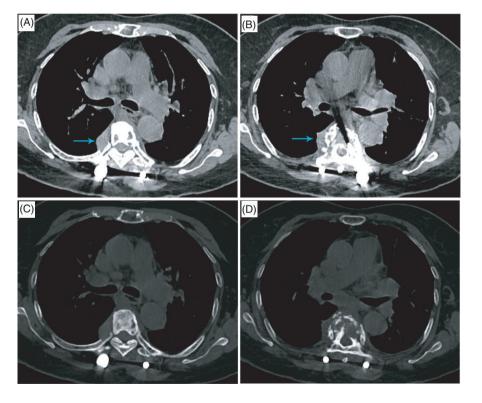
Preoperative and postoperative X-ray examinations during the second surgery in October 2020. (A) The arrow points to the preoperative T6 focal vertebral body in the coronal plane. (B) The arrow points to the preoperative T6 focal vertebral body in the sagittal plane. (C) The arrow points to the postoperative T6 focal vertebral body in the coronal plane. (D) The arrow points to the postoperative T6 focal vertebral body in the sagittal plane.
